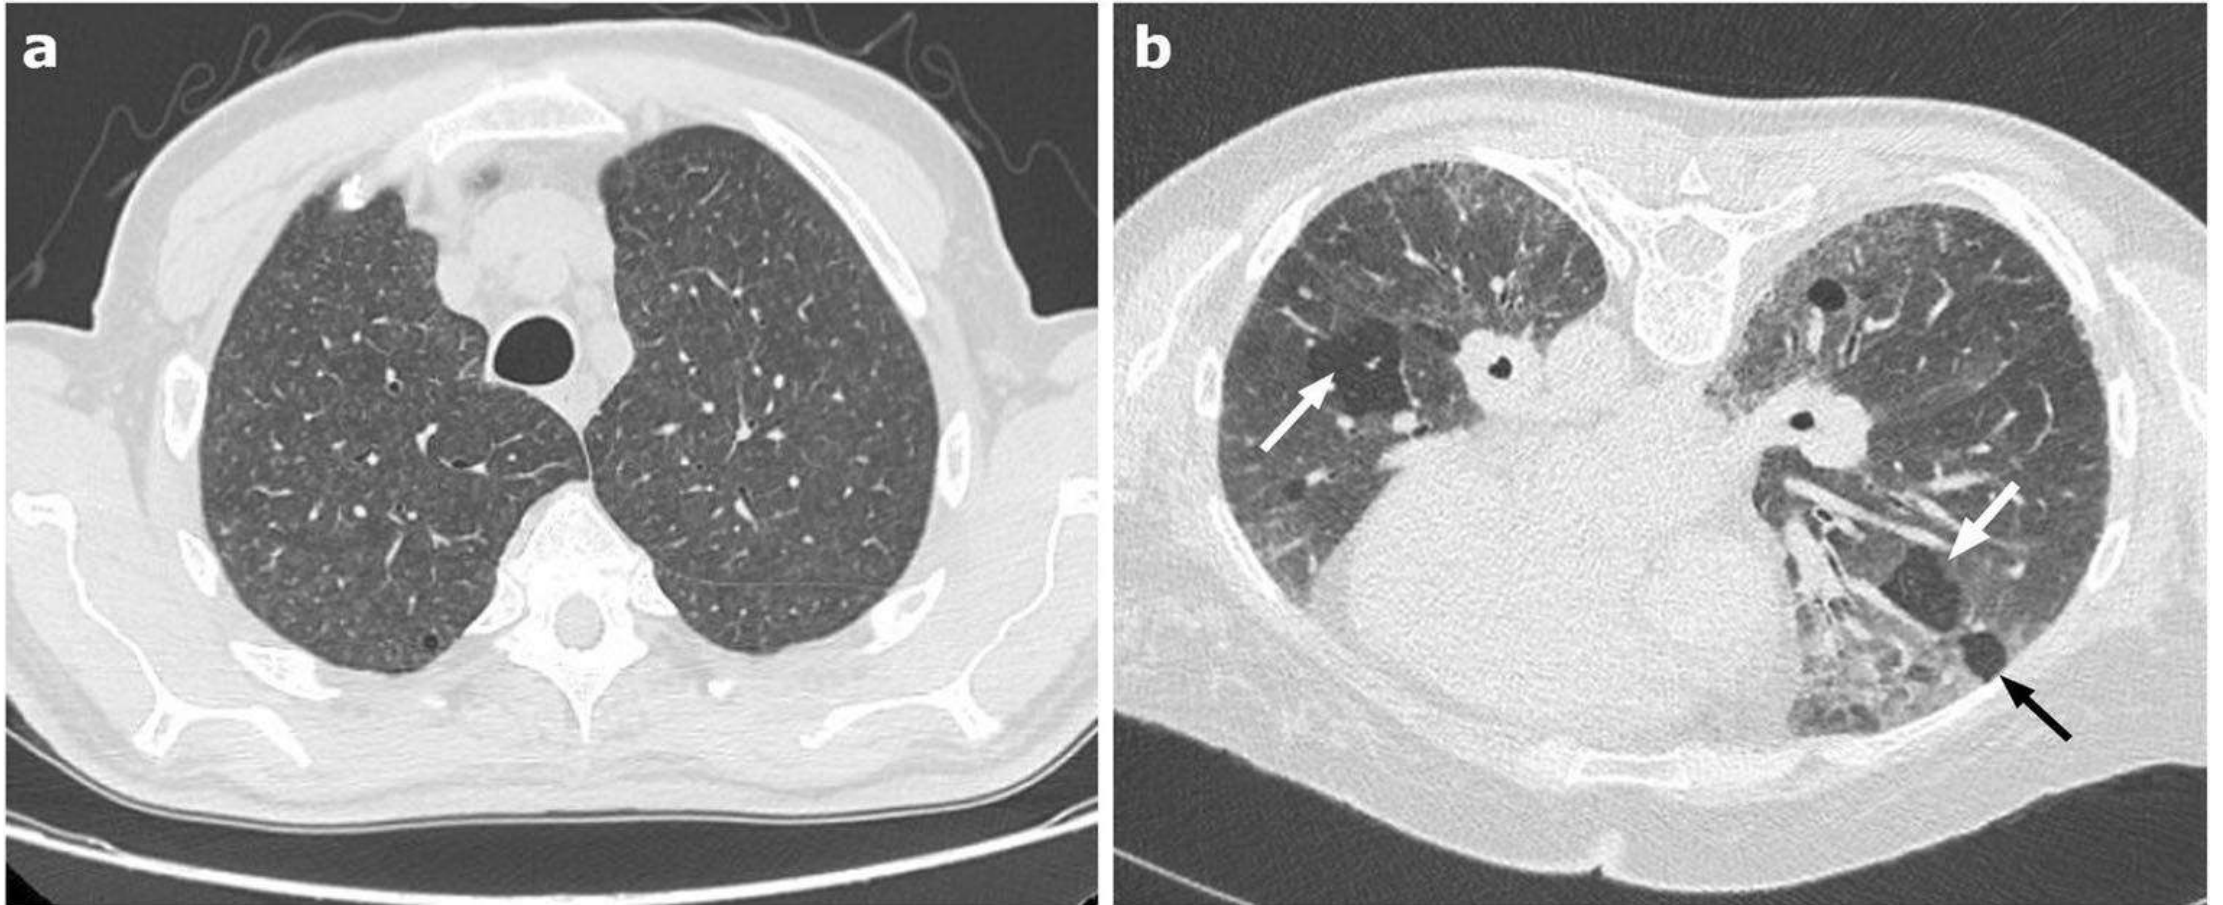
a–b Axial supine (a) and prone (b) HRCT images of a patient with non-fibrotic hypersensitivity pneumonitis showing small bilateral ground-glass centrilobular nodules (a) and bilateral patchy ground-glass opacities with lobular air-trapping (arrows in b) resulting in a mosaic pattern attenuation
